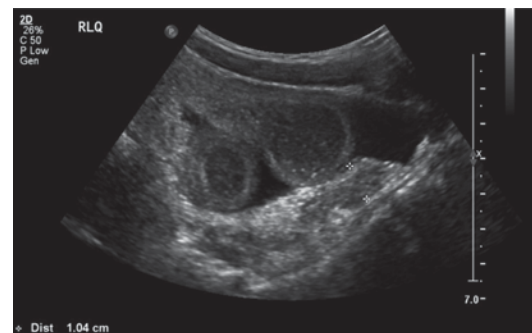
Jejunal atresia: 2-day-old male with intestinal atresia type 4, total of 15 atretic segments. Ultrasound shows multiple dilated loops of bowel
